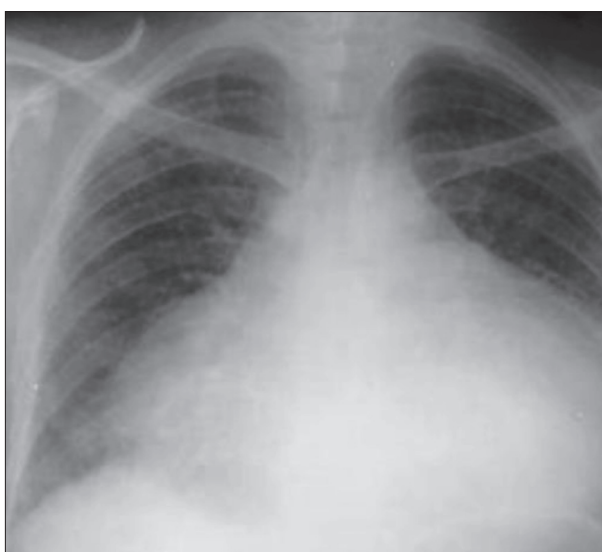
Radiography finding in pericardial effusion
